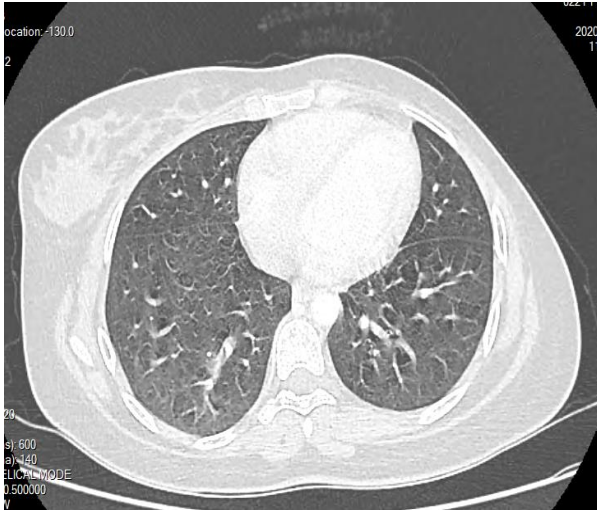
Right inferior accessory fissure. The HRCT scan through lower lobes show right inferior accessory fissure that begins from the major fissure and extends posteriorly. Its posterior portion is incomplete.
